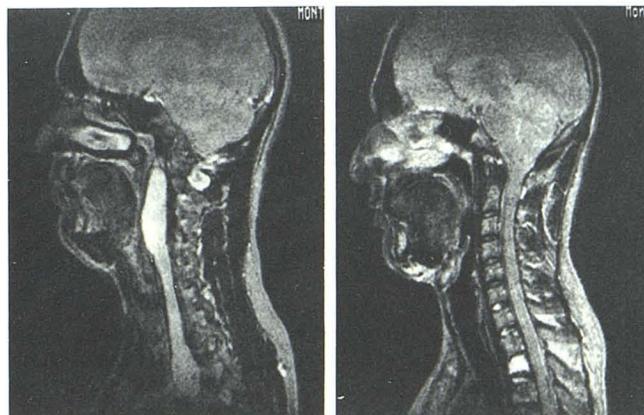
MR imaging with SE 1200/50 showing high-intensity prevertebral lesion extending from upper thoracic to nasopharynx.
